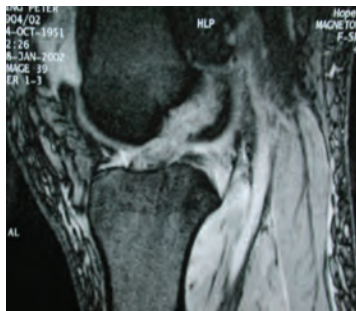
MRI scan of the knee showing a tear of the ACL. The normal ACL is a black structure on an MRI scan, whereas on this scan it is all white (bleeding) with no fibres seen running through it. (ortho pics - ACLuk)
